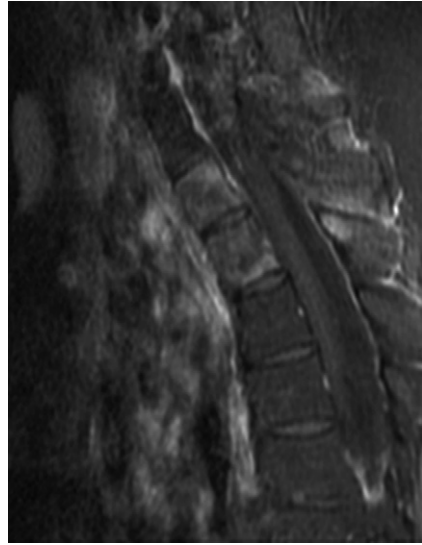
Case 1: 22-year-old female with known history of osteosarcoma who was noted on bone scan to have increased uptake at both T1 and T2 vertebral bodies. Two-level spondylectomy undertaken. Sagittal T1-weighted MRI with gadolinium demonstrated both T1 and T2 vertebral body involvement.
